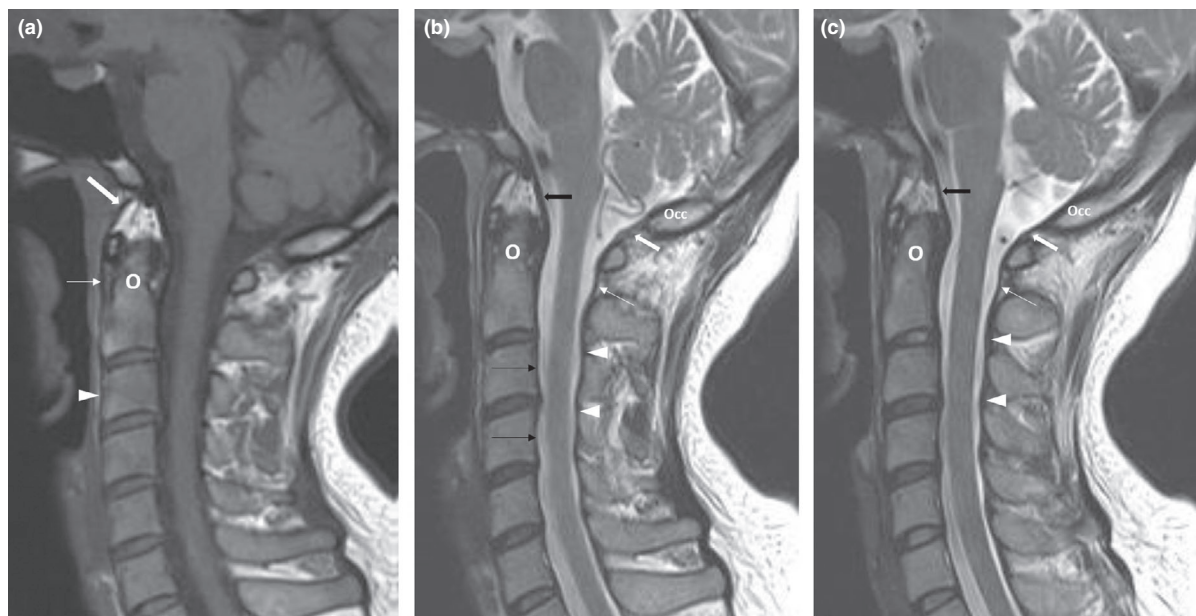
(a) Mid-sagittal T1W MR image shows the normal anterior atlanto-occipital membrane (AAOM – thick arrow), anterior atlanto-axial membrane (AAAM – thin arrow) and the anterior longitudinal ligament (ALL, arrowhead), best seen on the sagittal plane. These membranes are normally hypointense on T1 and T2W images and are not separately discernible from the adjacent bony cortex or intervertebral disc. (b) and (c) Contiguous mid-sagittal T2W MR images show the normal posterior atlanto-occipital membrane (PAOM- thick white arrow), posterior atlanto-axial membrane (PAAM- thin white arrow), and the ligamentum flavum (arrowheads), all best seen on sagittal plane. These membranes are normally hypointense on T1 and T2W images. The tectorial membrane (thick black arrow) and PLL are depicted (thin black arrows). The normal PLL is not separately discernible from the adjacent bony cortex or the disc. The odontoid peg (O) and posterior occiput (Occ) are also depicted.
